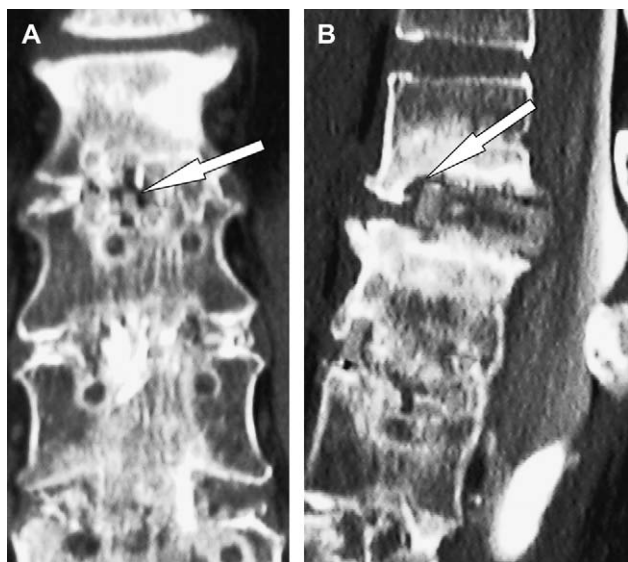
(A) Patient 9, a 48-year-old woman with nonunion L1–L2 above previously healed L2–L5 posterior lumbar interbody fusion. Computed tomography 12 months after L1–L2 implant removal and bone morphogenic protein augmentation of posterior-lateral fusion; computed tomographic coronal reconstruction of L1–L2: an arrow demonstrates a lucency running horizontally through the fusion mass within the interbody cage. (B) Computed tomographic sagittal reconstruction: arrow shows lucency around a cage with 2 mm retropulsion of the cage into the canal.
